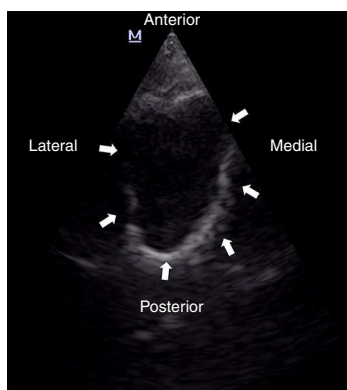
Right maxillary sinus ultrasound, phased-array probe, demonstrating a well-defined hyperechoic walls of the right maxillary sinus (arrows). This sign is denominated “complete sinusogram”.
